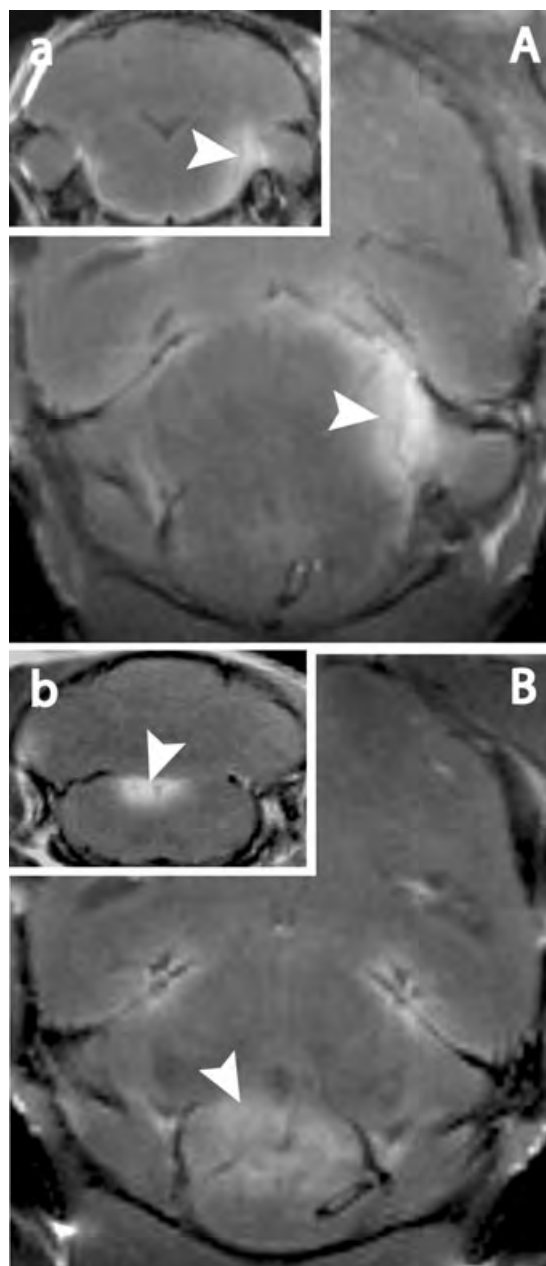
Inflammation of cranial nerve fascicles and nuclei was a frequent finding. Axial (A, B) and coronal (a, b) T1-weighted images are presented post-Gf application. Contrast enhancement is visible at the left trigeminal nerve fascicle (A, a) and in the area of the vestibulo-cochlear nuclei (B, b).
